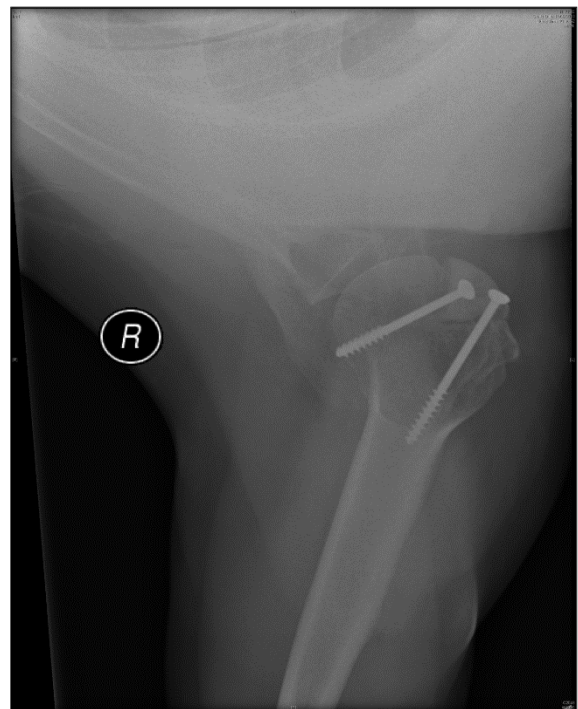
Immediate postoperative anteroposterior radiographs (Patient 3) showing normal humeral head shape and excellent joint congruency
